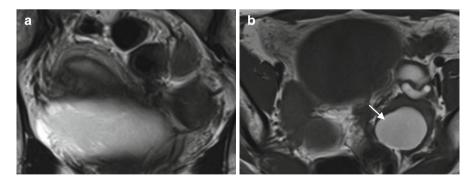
(a) is a T2-weighted oblique coronary image and (b) is a T1-weighted axial image of the same person, in which a right unicornuate uterus and a left rudimentary uterus clearly appeared. The unicornuate uterus on the right is fully developed, and the distinct signal represents the three layers of the uterine body that can be easily detected; the rudimentary uterine on the left does not connect with the contralateral; hemorrhage within the cavity has a hyperintense signal upon T1 (*white arrow*)
